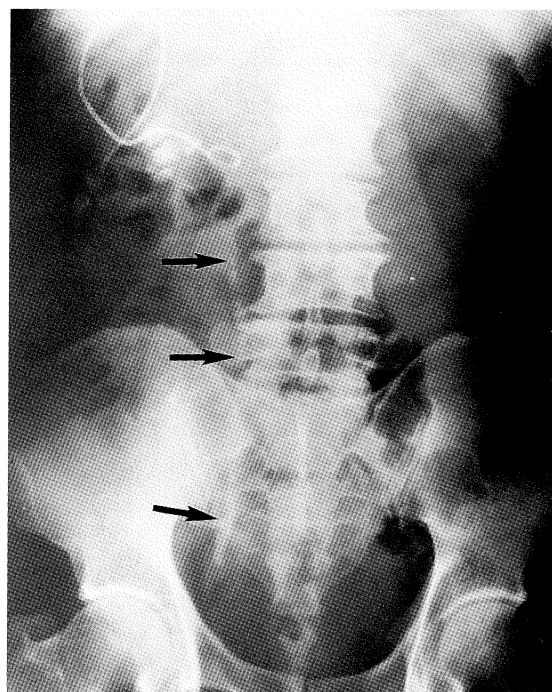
Radiograph following external drain placement shows steinstrasse formation after ESWL. A line of stone fragments is seen (arrows).
